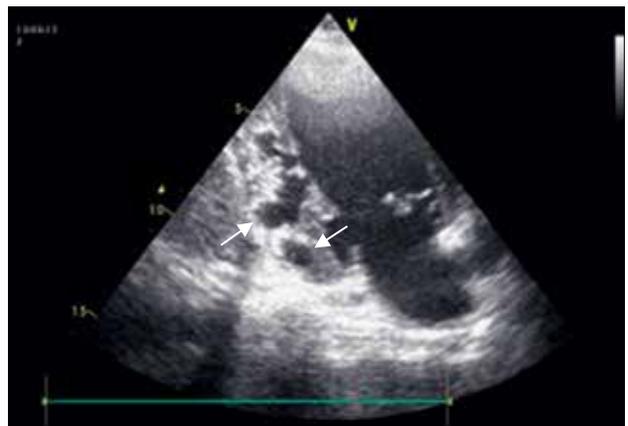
Transthoracic echocardiography. Apical two-chamber view. Additional cavity within the left ventricle – subdivision of the left ventricular cavity by an abnormal septum into 2 chambers; fenestrations and lacunae within the pathology (arrows)
